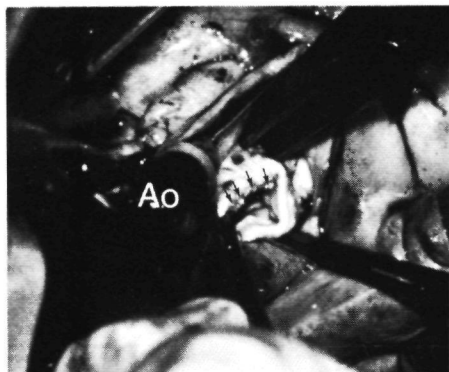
Echocardiogram and operative photograph from case 26, with pre-existent calcific aortic valve stenosis, and aortic regurgitation occurring after IE.
